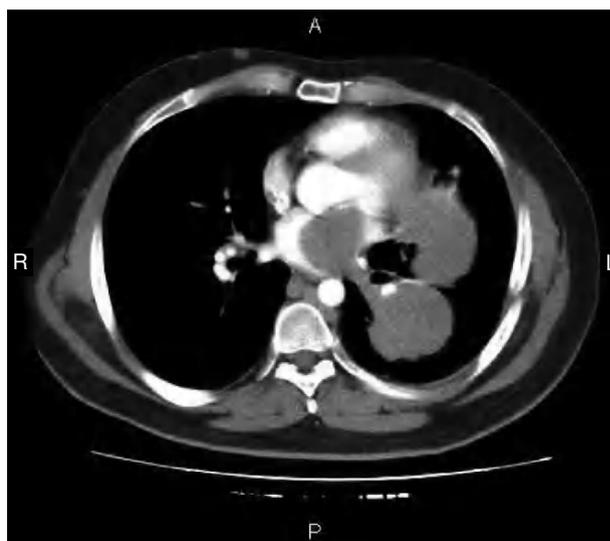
Computed tomography slice showing an atrial tumor that had extended from the left pulmonary veins.
